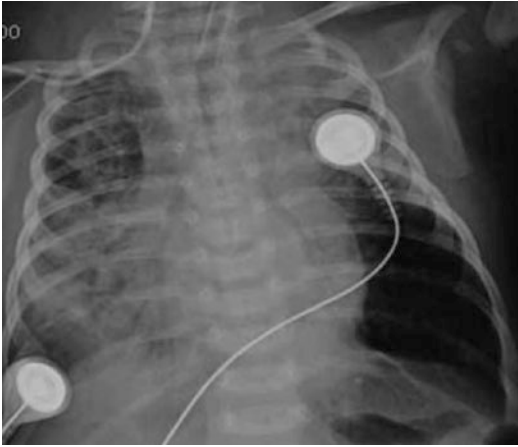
Deep Sulcus Sign. Decubitus anteroposterior chest X-ray in infant with severe pneumonia. It shows left pneumothorax with deep sulcus sign
